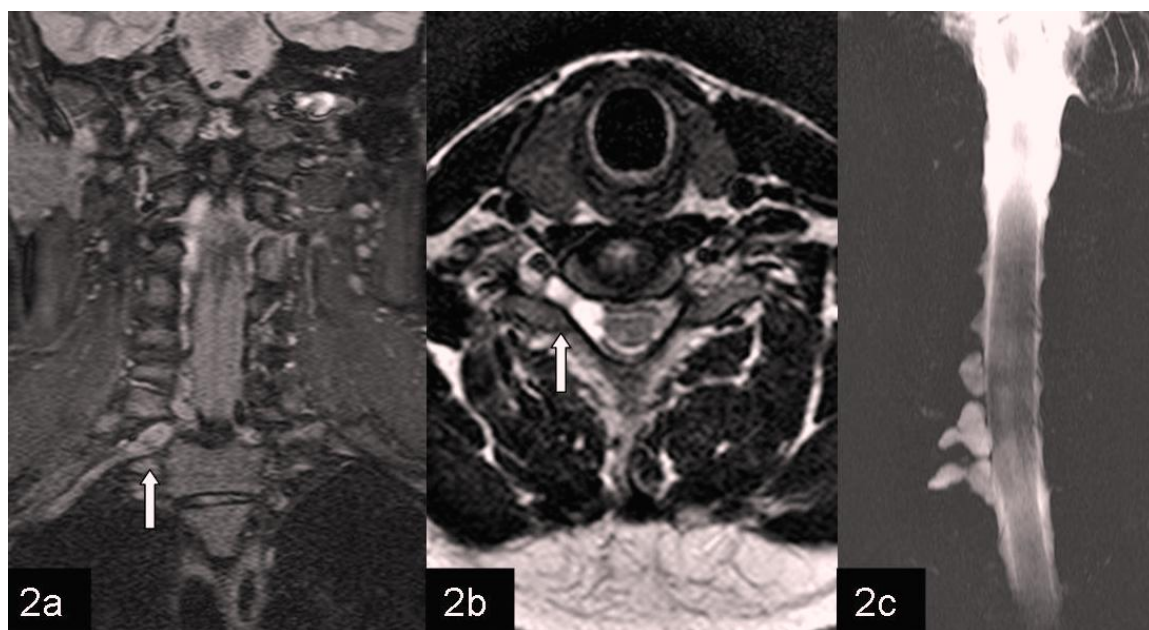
a-c: Coronal and axial T2-weighted fast spin-echo MRI and MR myelography. 2a-b. C8 right foraminal part of pseudomeningocele and nerve sheets dilatation (arrow). 2c. MR myelography images of pseudomeningocele.
